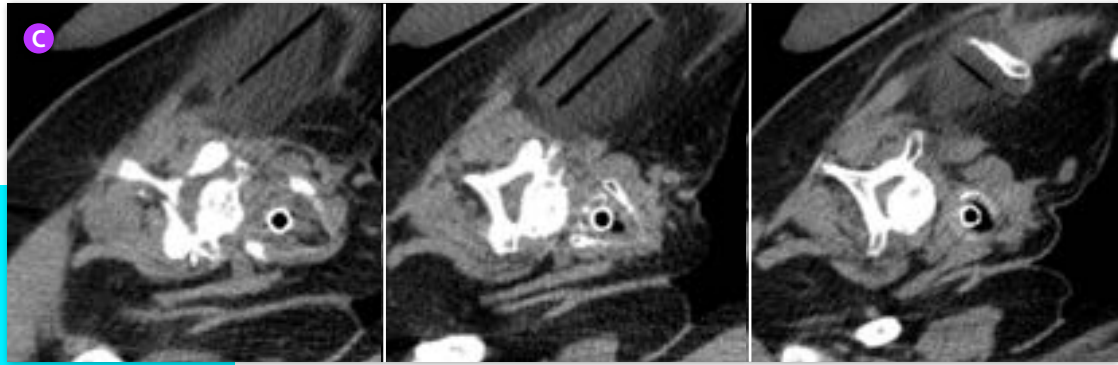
CT immediately post ablation showing complete coverage of the mass with a 5mm margin
